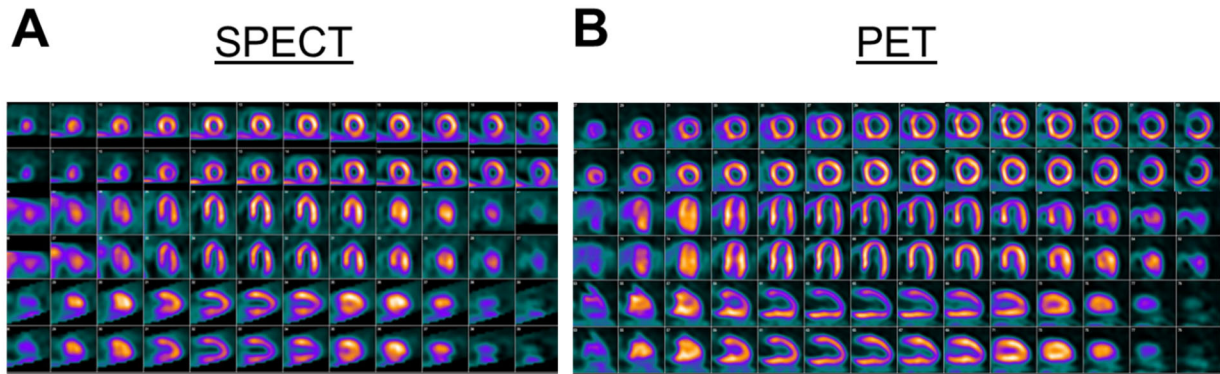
Case Example, Patient 301-139-008. Reformatted myocardial perfusion images (stress images above the corresponding rest images) of a 66 year-old female with LVEDV=82 mL. While the SPECT images (A) were interpreted as normal, the PET images (B) demonstrated anterior and lateral wall stress-inducible defects, consistent with underlying 82% stenosis in the LAD and 54% stenosis in the LCx.
